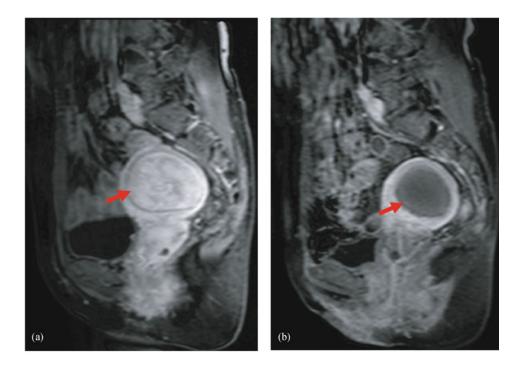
Contrast-agent-enhanced MRI from a patient with uterine fibroids. (a) Pretreatment image showing the fibroid with enhancement (arrow). (b) One month posttreatment, MRI showing the fibroid shrunk with no enhancement (arrow). MRI: magnetic resonance imaging.
